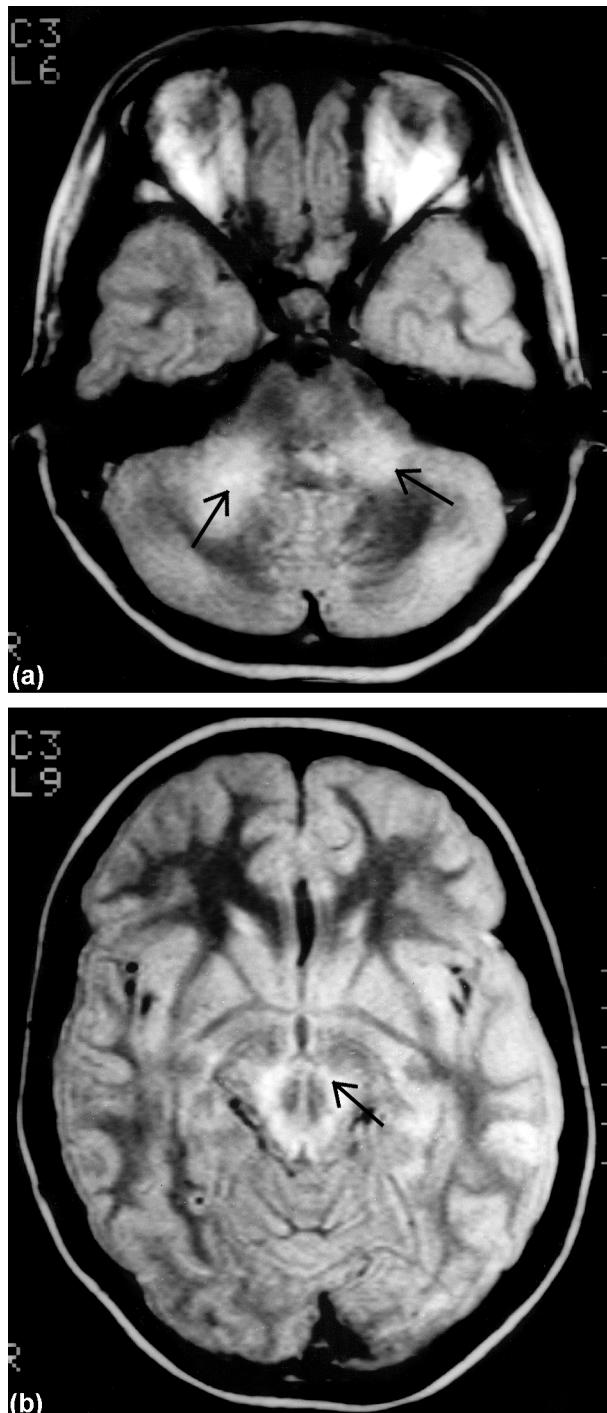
Young female (case 2). The first magnetic resonance image examination, proton density-weighted obtained at her admission. (a) High signal lesions bilaterally in the middle cerebellar peduncles extending posteriorly on the right side (arrows). Minor changes also in the pons. (b) Similar, symmetric changes also in the mesencephalon.
